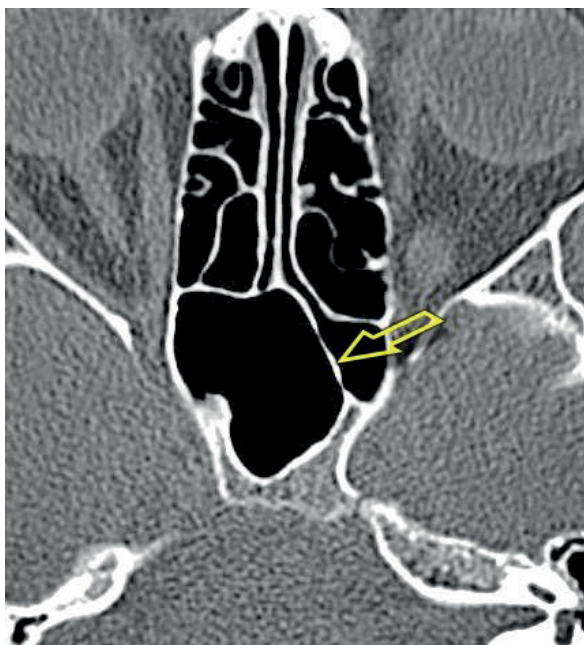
A CT scan of the paranasal sinuses, transverse plane. The shift of only the posterior part of the septum to the left.
